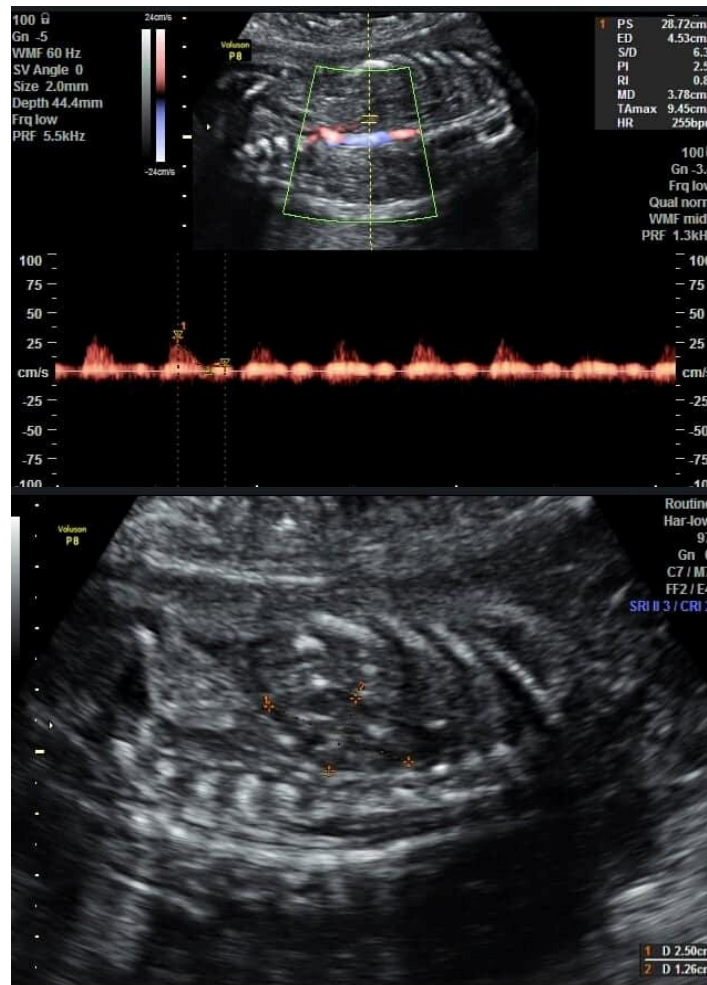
Ultrasound of IUGR fetus aged 28 weeks show renal measurements and fetal renal Doppler
